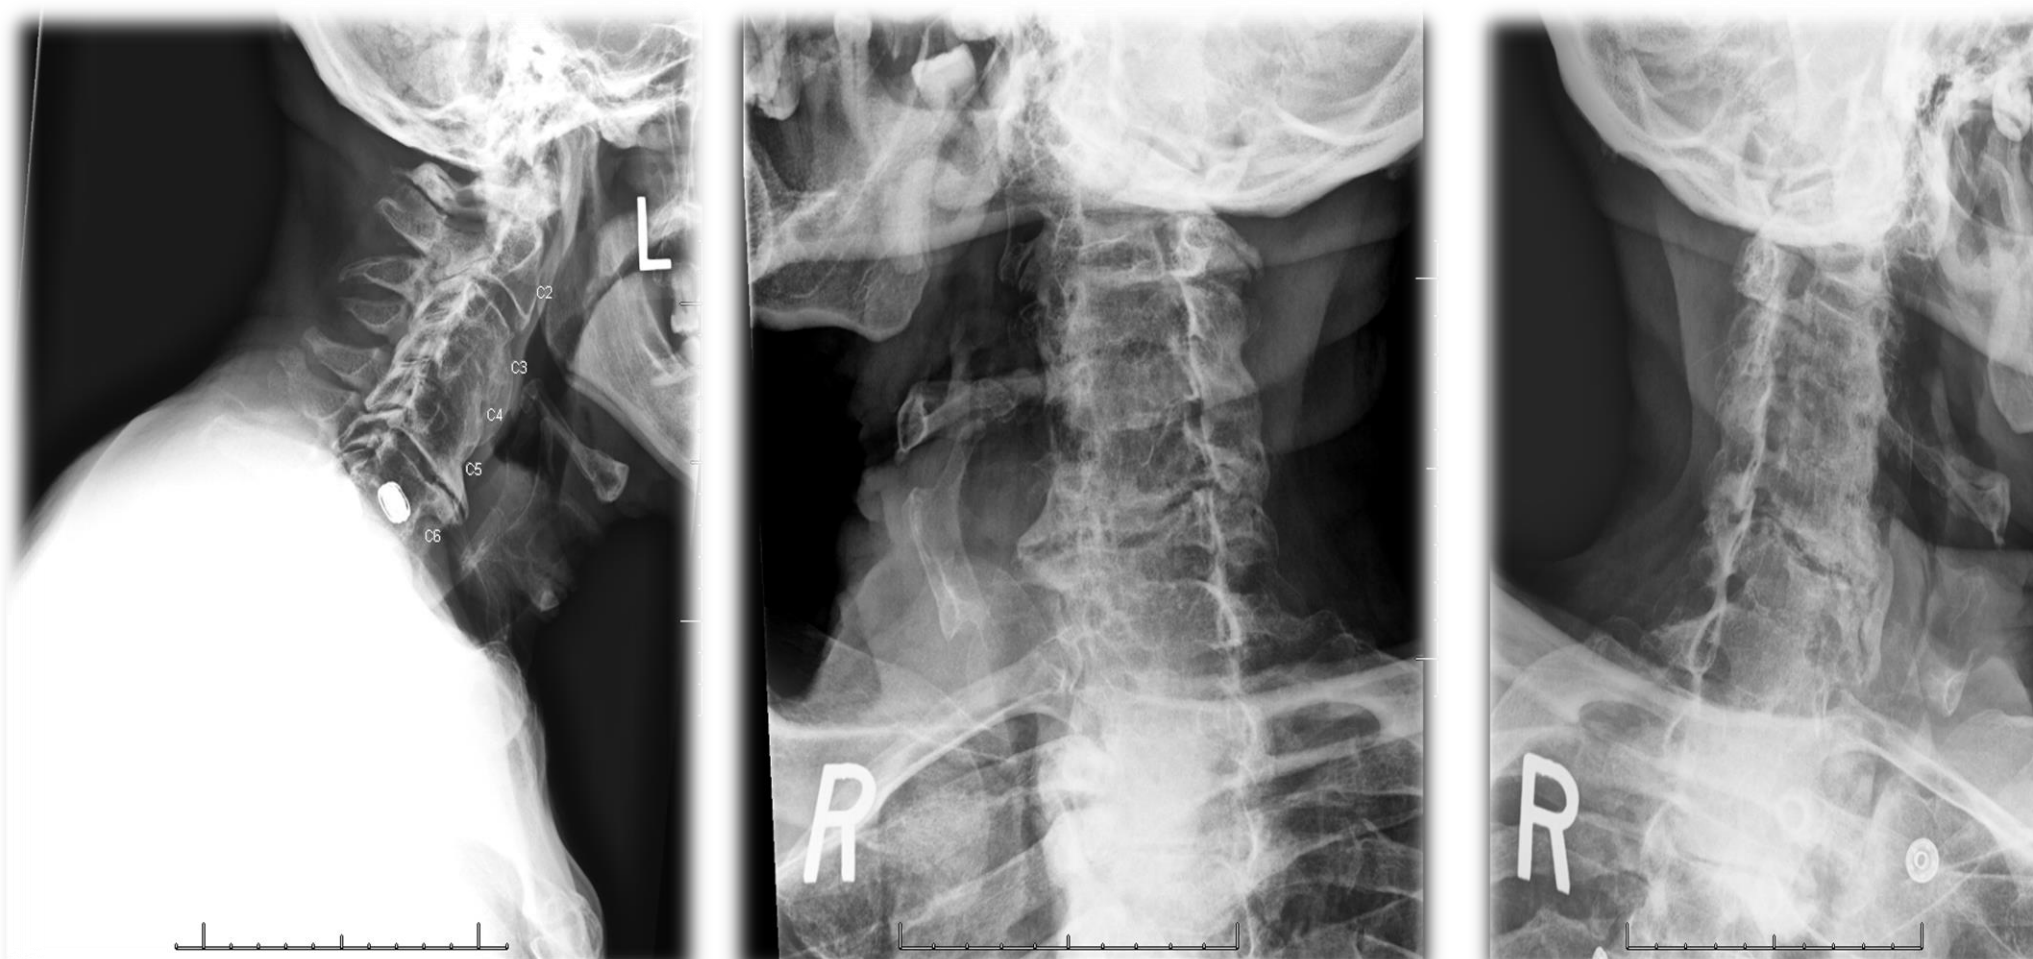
Lateral and oblique cervical spine radiographs obtained one week preoperatively
